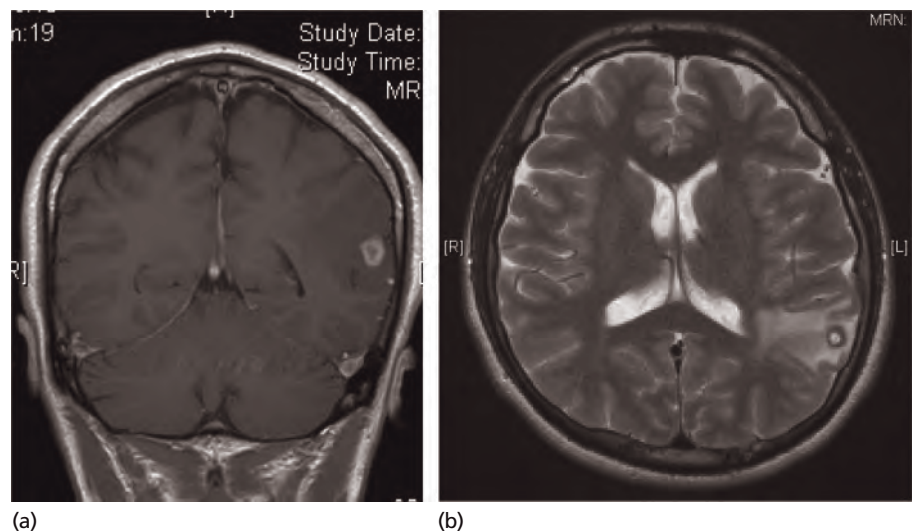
Isolated lesion of neurocysticercosis shown on: (a) MRI T1W; and (b) MRI T2W.
